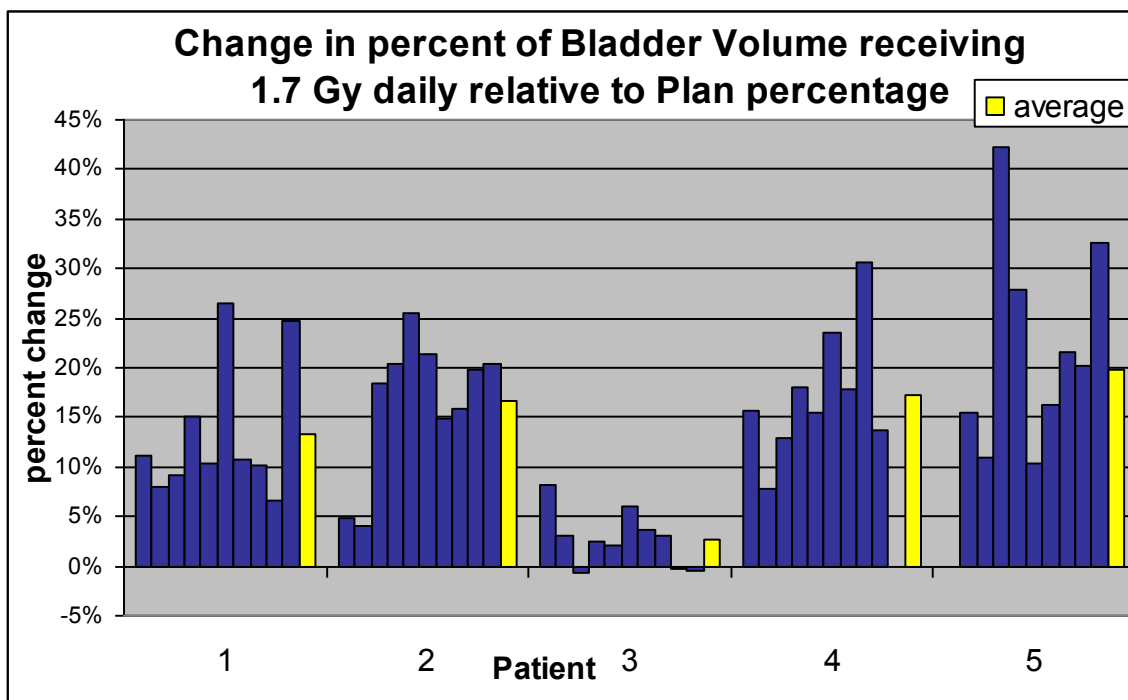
Change in percentage of bladder volume receiving 1.7 Gy relative to the treatment plan value listed by patient. Positive values indicate an increase in the volume of bladder receiving 1.7 Gy, while negative values indicate a decrease in bladder volume at that dose. Each column represents data from one selected daily cone beam scan per consecutive week of treatment. The average for these values over the course of treatment is shown in yellow.
